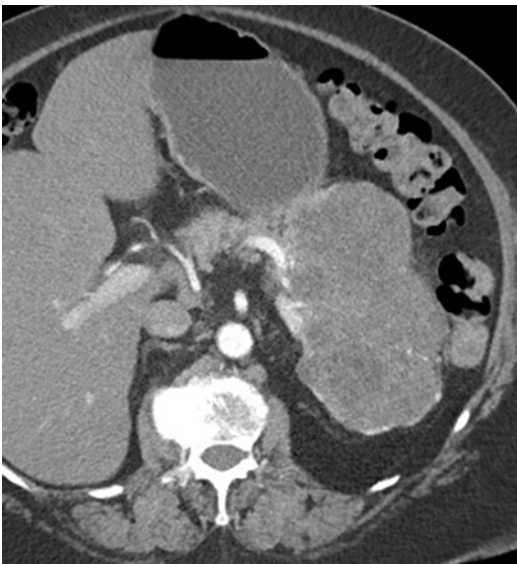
Axial contrast-enhanced CT demonstrates the classic “sponge” appearance of a serous cystadenoma. Notice the lobulated contour of the mass, classic for this entity
